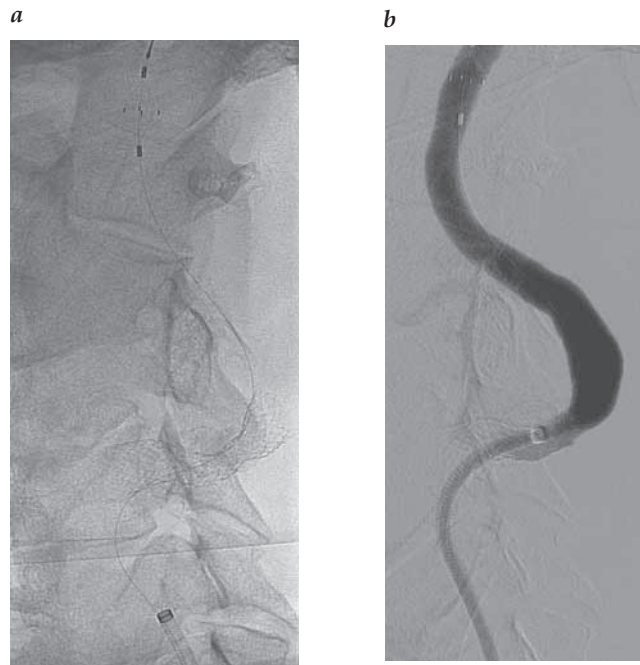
Severe angulation of the carotid bifurcation. (a) X-ray image showing the position of the stent and the distal filter element. (b) Advancement of the sheath over the wire and retrieval catheter were necessary to allow for the capture of the embolic protection device.
